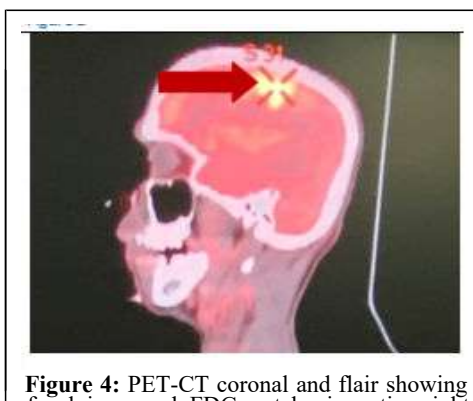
PET-CT coronal and flair showing focal increased FDG uptake in entire right pre-central gyrus.
